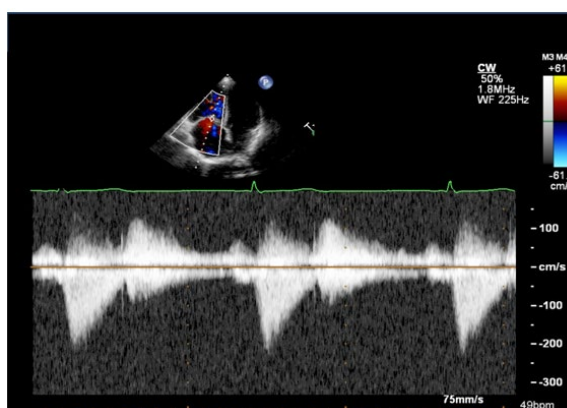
Continuous wave Doppler through the tricuspid valve showing severe tricuspid regurgitation with a characteristic triangular envelope due to rapid equalization of pressure between right atrium and right ventricle.
